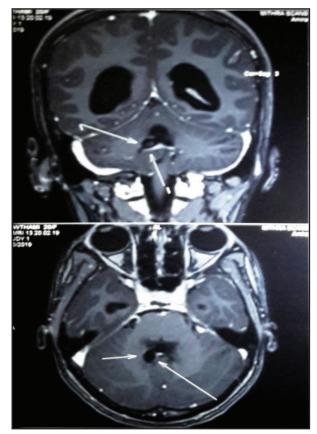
T1 contrast MRI Brain axial and coronal cut showing cystic lesion in 4th venticle with obstructive hydrocephalus.
